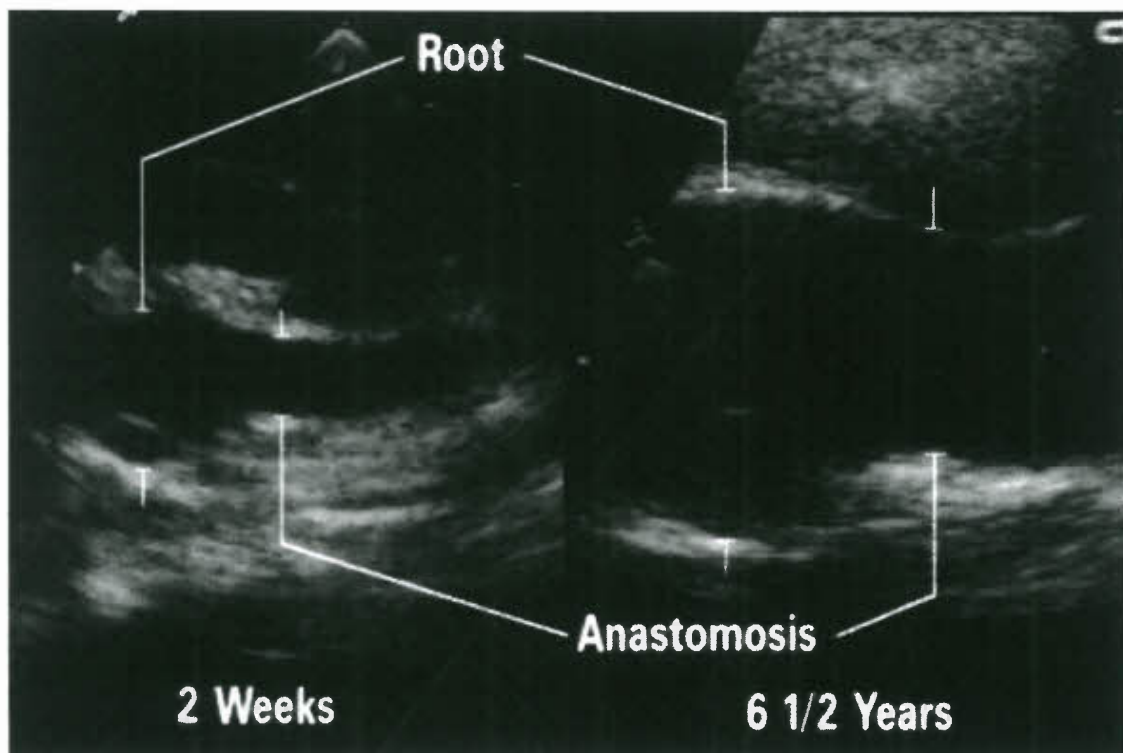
Echocardiographic images of the neo-aortic root and the aortic anastomosis at 2 weeks (left) and 6 1/2 years (right) after arterial switch. Note that the anastomosis is well seen at 2 weeks but is indistinguishable from the rest of the ascending aorta at 6 1/2 years. (From Hourihan M, Colan SD, Wernovsky G, et al. Growth of the aortic anastomosis, annulus and root after the arterial switch procedure performed in infancy. *Circulation* 1993;88:615–620, with permission.)
